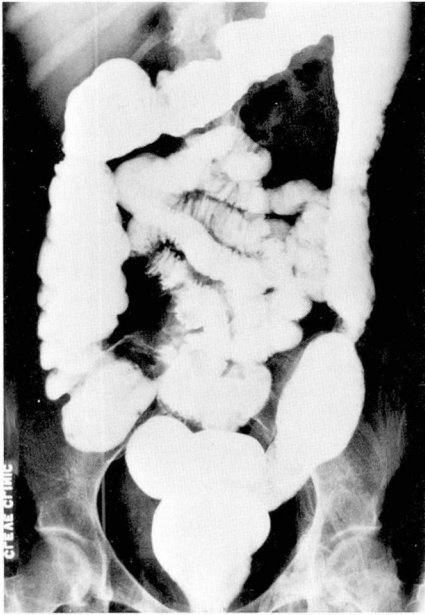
Roentgenogram of the colon after barium enema, July 1968. Residual ulceration in descending colon but improvement from previous study. Note lack of shortening of colon.
